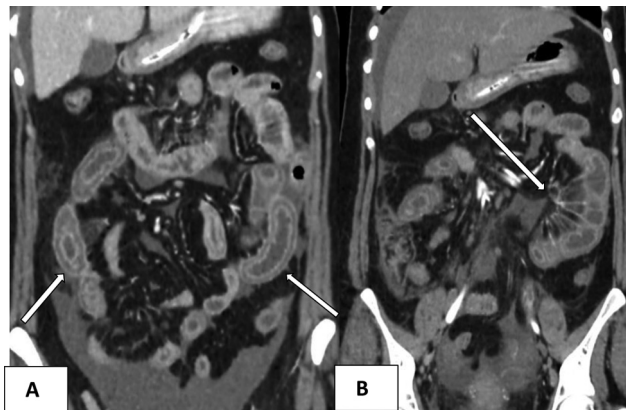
Coronal sections of contrast-enhanced computed tomography (CECT) of the abdomen performed on the day of admission. (A) Bowel wall thickening with heterogeneous enhancement giving target appearance (arrows). (B) Engorged mesenteric vessels arranged in a comb-like arrangement, comb sign (arrows).
